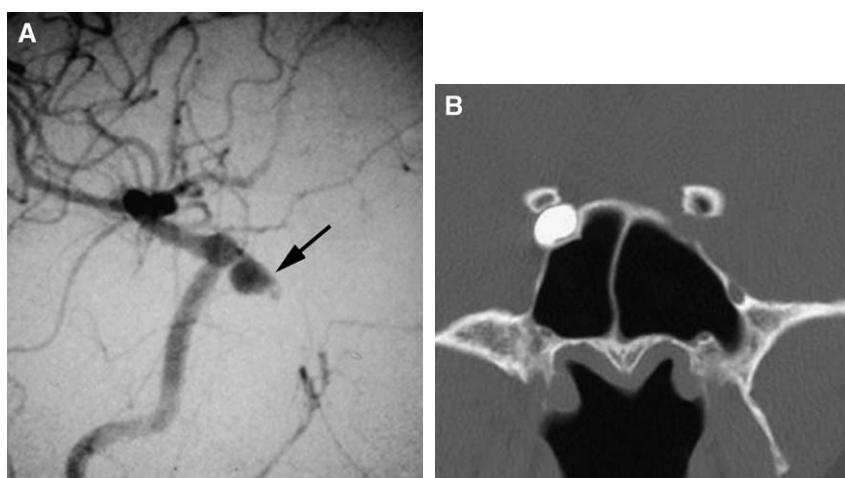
(A,B) Intraoperative bleeding encountered during sphenoid sinus surgery. After packing, the angiogram revealed a pseudoaneurysm (arrow) treated with carotid occlusion. CT demonstrates the occlusive coil pack balloon position relative to the sphenoid sinus.
